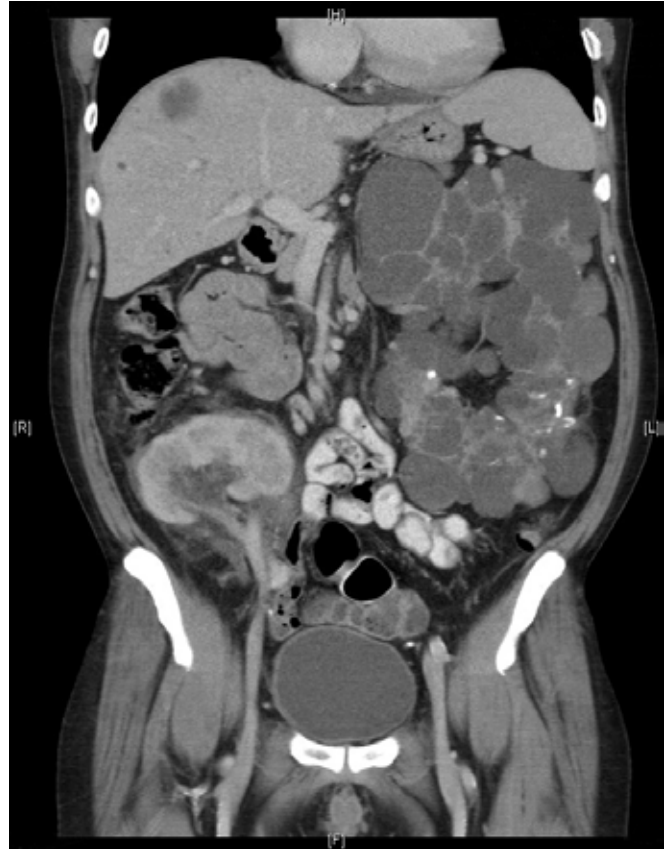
CT image shows a well-perfused left lower transplant kidney with its hilum.
